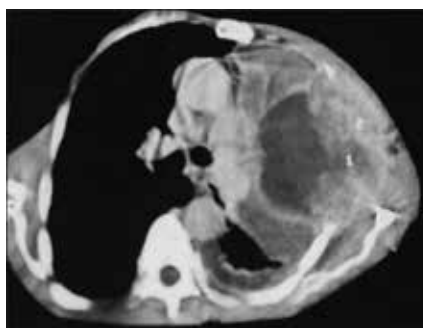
Computed tomography of the thorax revealed a well defined pleural based hypodense lesion of variable size noted on left side.
